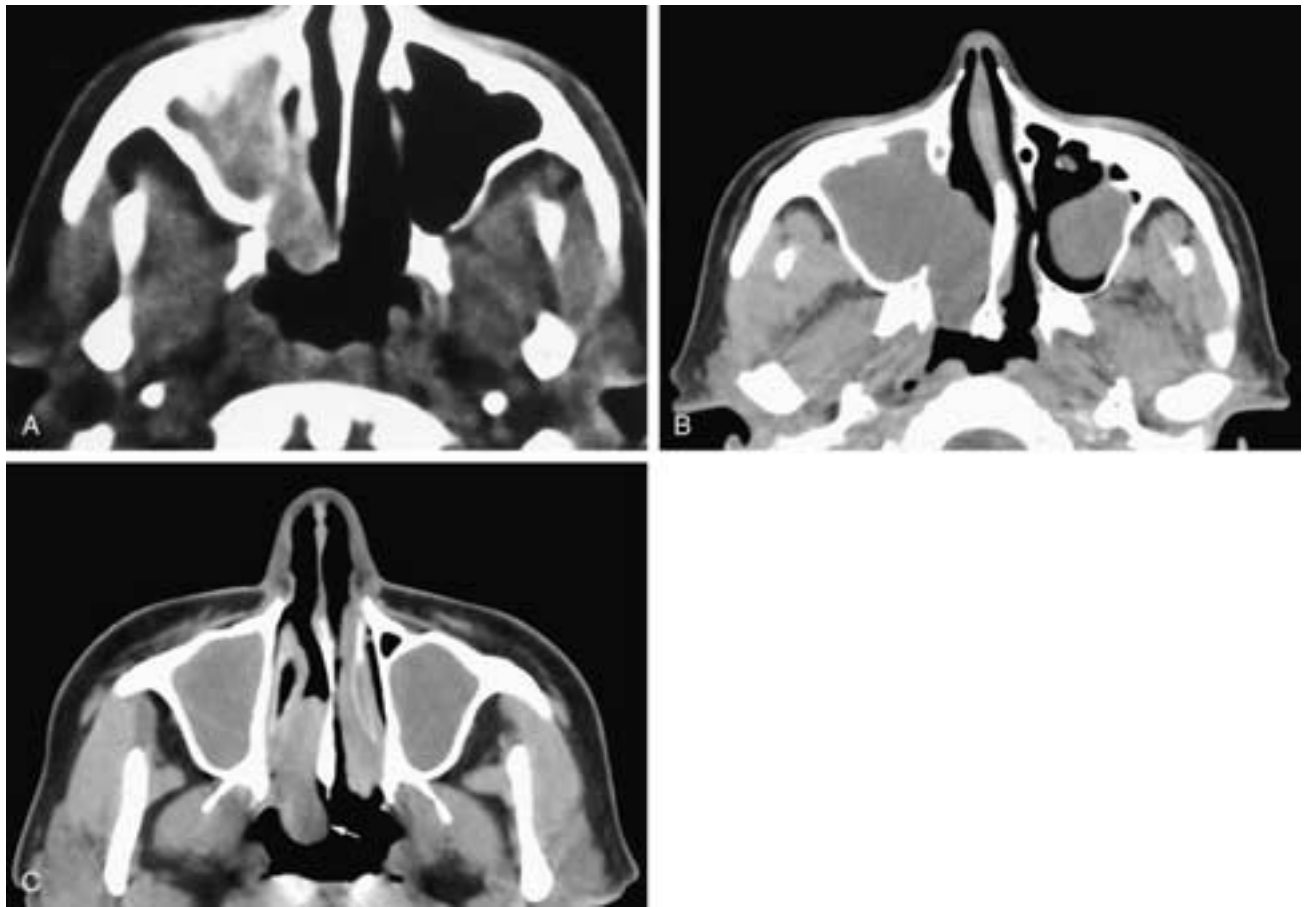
A, Axial CT scan shows a right maxillary sinus polypoid mass that has prolapsed into the posterior right nasal fossa. This patient had an antrochoanal polyp. Axial cranial (B) and caudal (C) CT scans on another patient show a polypoid mass in the right maxillary sinus that has extended into the right nasal fossa and prolapsed into the nasopharynx (*arrow*). This patient also had an antrochoanal polyp.
